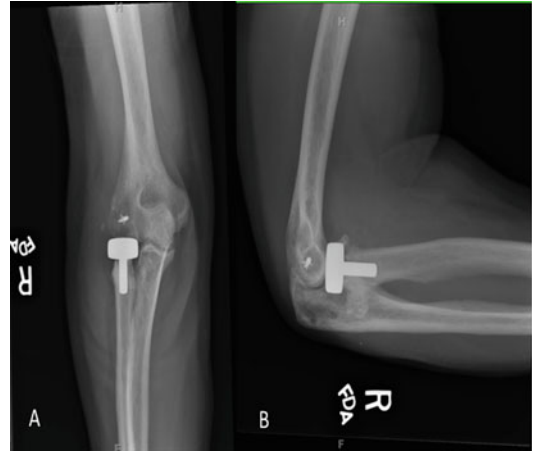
X-rays of a radial head arthroplasty (a) Anterior-posterior (b) Lateral
